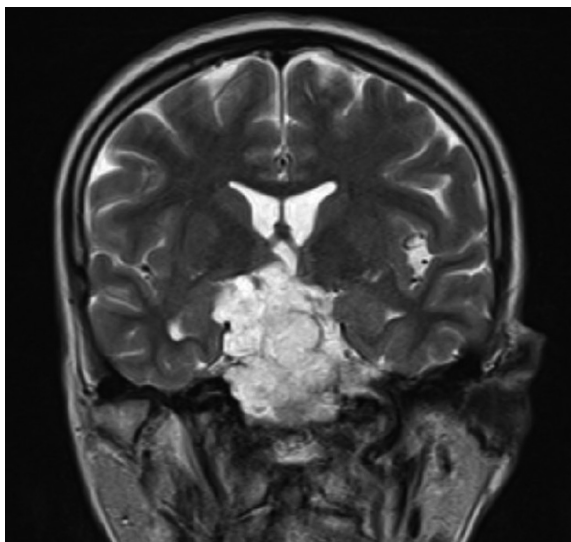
Heterogenous hyperintense signals were obtained in the lesion on the coronal plane T2-weighted image.
